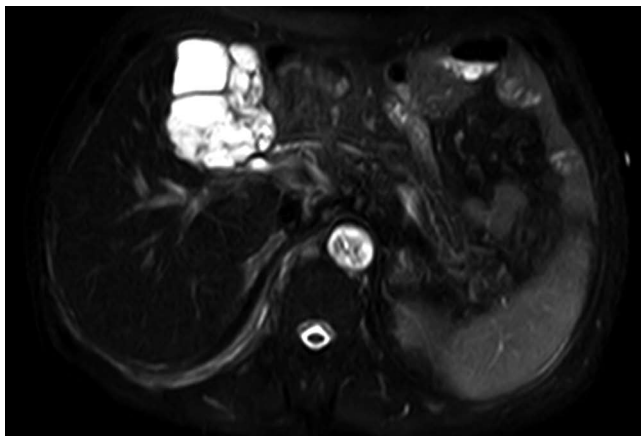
Axial T2-weighted magnetic resonance (MR) image showing a thin multi-septated cystic mass (high-signal intensity) with scalloping margin.
